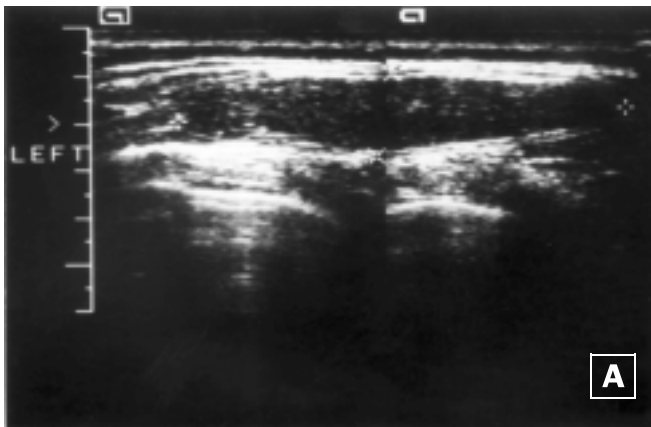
Longitudinal sonogram of Achilles tendon, demonstrating a lipoma [A]. Note the disorganized arrangement in comparison to the normal tendon [B].
